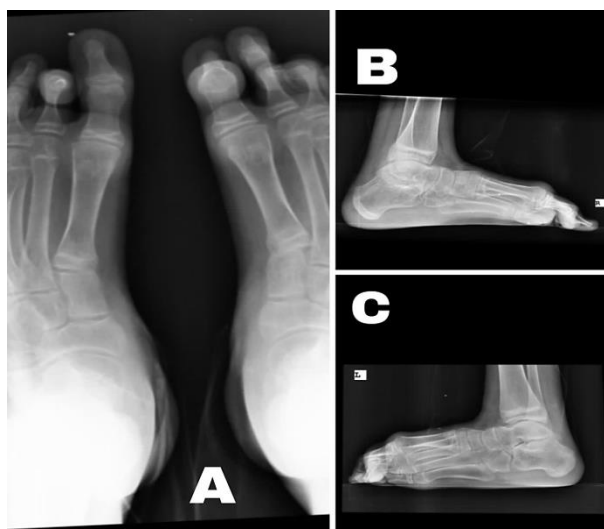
X-rays of the feet showing flexion contracture of the proximal interphalangeal (PIP) joints of the toes
